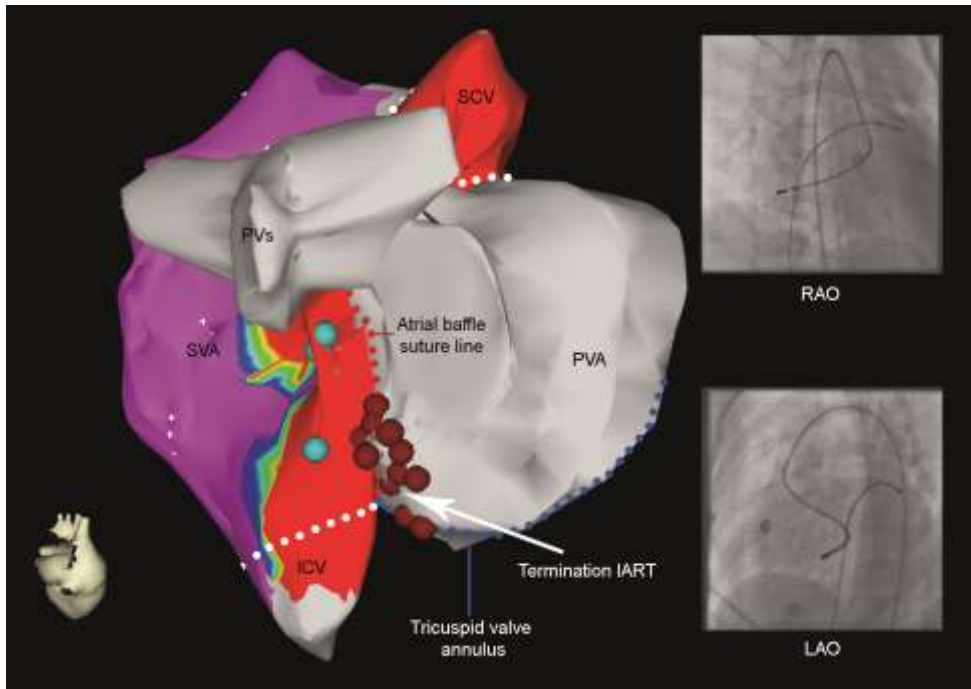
Map containing voltage data of the systemic venous atrium (SVA) and anatomical data acquired with intracardiac echocardiography (seen from a right posterior oblique view; color coding similar as in figure 2). The ablation catheter was positioned inside the pulmonary venous atrium using a retrograde approach. A linear radiofrequency (RF) lesion connecting the tricuspid valve annulus and inferior caval vein resulted in prolongation of the intraatrial reentrant tachycardia (IART) cycle length and eventually in IART termination (red dots represent RF ablation sites, white arrow indicates site of termination). Insets: catheter position during termination of the tachycardia on a fluoroscopic right anterior oblique (RAO) and left anterior oblique (LAO) view.
